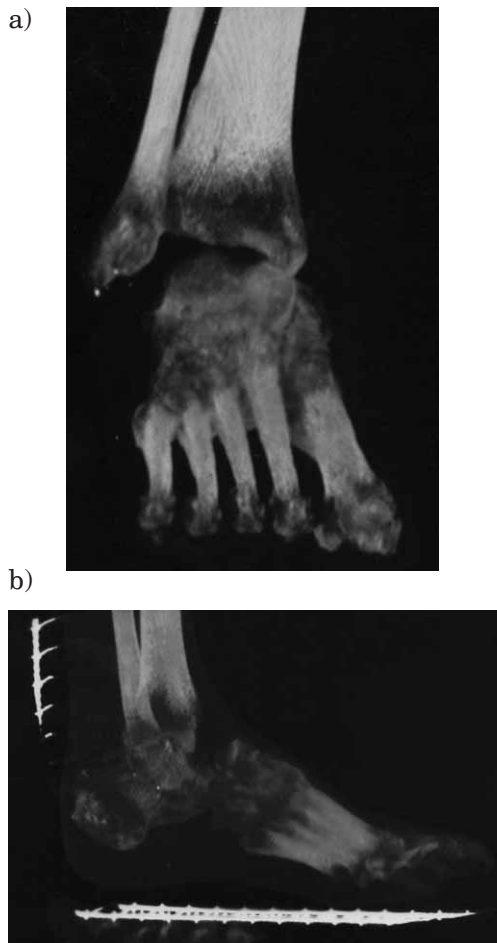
a) and b) Frontal and lateral CT of the ankle, taken immediately after injury, showed total talar dislocation.
